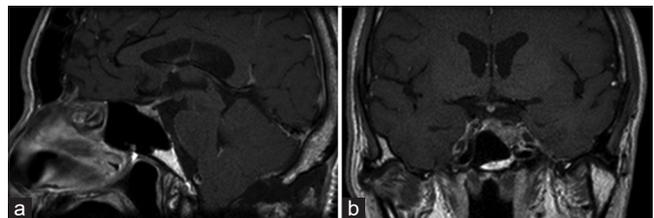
(a & b) T1-weighted image on magnetic resonance imaging showed pituitary adenoma.
